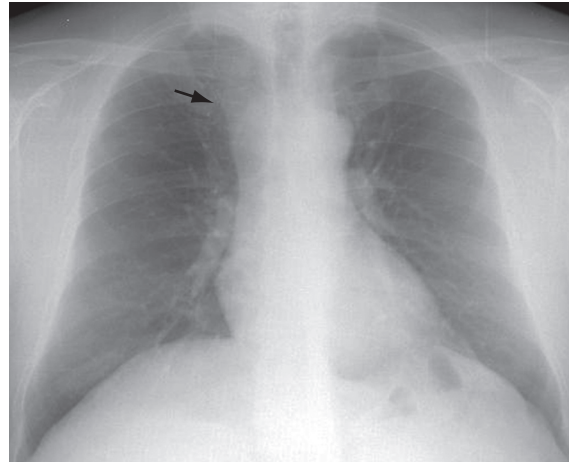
Chest X-ray showing a right paratracheal opacity (arrow).
